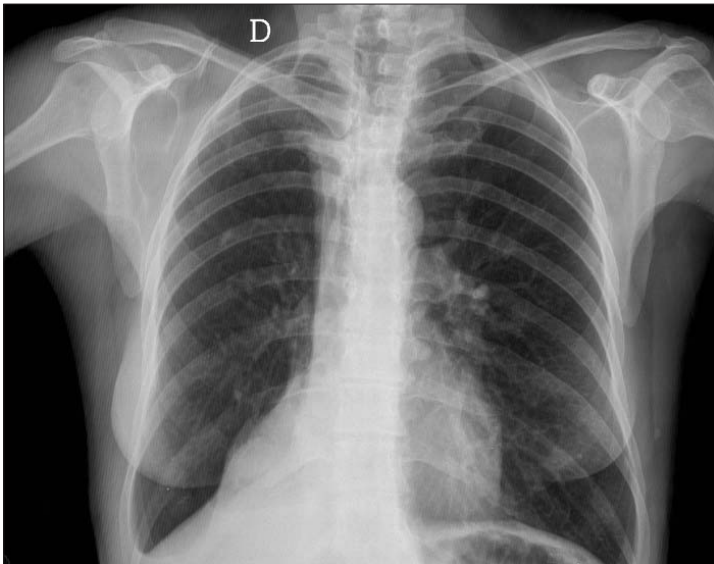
Chest radiograph: paramediastinal parenchymal opacity may be noticed in the right basal zone with asymmetry of pulmonary fields due to volumetric reduction of right hemithorax.
